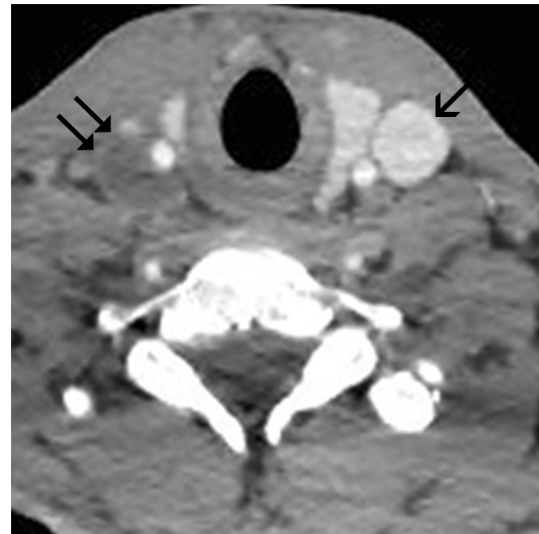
A 30-year-old male patient, known to have testicular cancer with lung and liver metastases, was referred for subcutaneous port insertion. Review of previous CT images showed a thrombosed *right* jugular vein (*double arrow*) and right subclavian vein, with a patent superior vena cava. The patent *left* internal jugular vein (*arrow*) was selected in advance for port insertion, decreasing the likelihood of procedure failure and reducing potential radiation exposure
